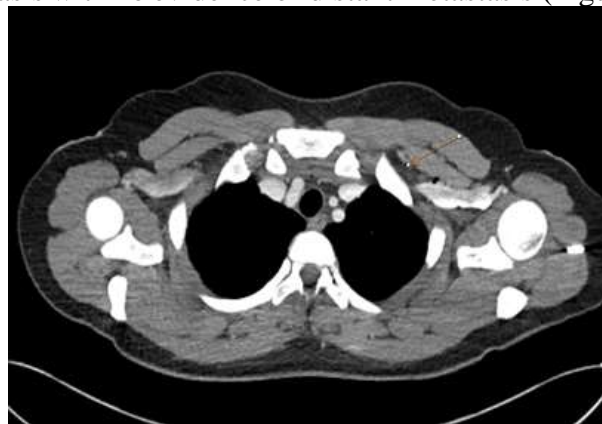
Preoperative staging CT scan showing no enlarged infraclavicular lymph node
